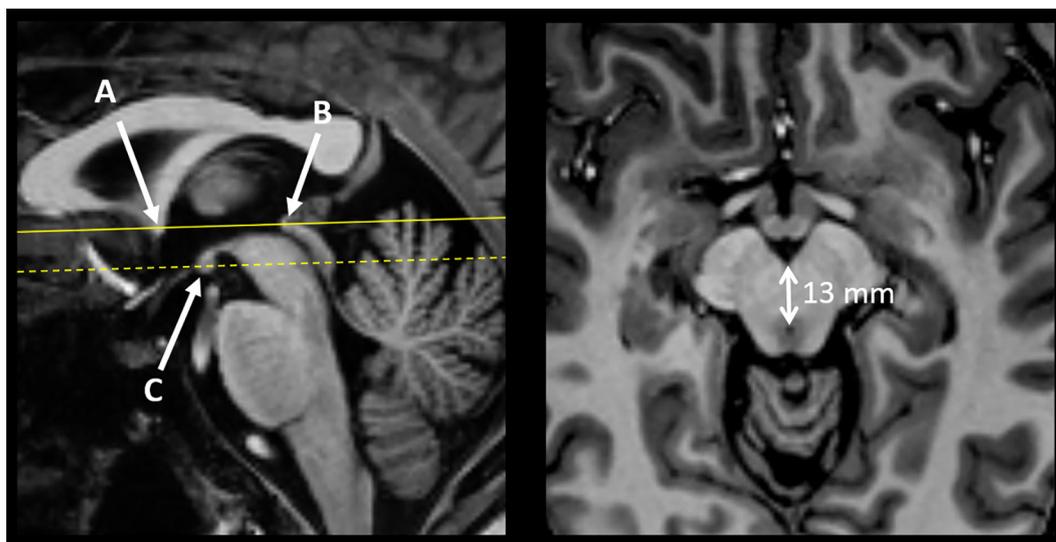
Measurement of the midbrain anterior-posterior diameter. *Left:* Midsagittal plane from a T1-weighted MPRAGE sequence. The solid yellow line is the anterior commissure (A)-posterior commissure (B) line. The dashed line is parallel to the anterior commissure-posterior commissure line and passes through the center of the mammillary body (C). *Right:* Axial-oblique plane parallel to the dashed line in the left figure. The midbrain anterior-posterior diameter is measured from the interpeduncular fossa to the anterior margin of the cerebral aqueduct. In this example, the diameter is 13 mm. (Images obtained at 7 T using an MP2RAGE sequence.)
